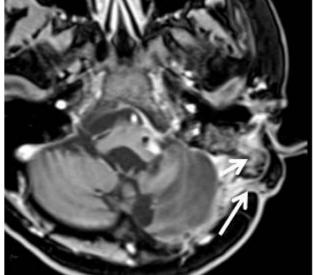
(a) Plain computed tomography scan of the brain (axial cut) showing a defect in the posterior wall of left mastoid with opacified mastoid air cells (short arrow) and sinus tract (long arrow); (b) axial enhanced T1-weighted magnetic resonance imaging scan showing enhancing sinus tract (long arrow) extending to extradural region close to the sigmoid sinus. The short arrow points to hyperintense bone wax and granulations in the mastoid air cells.
